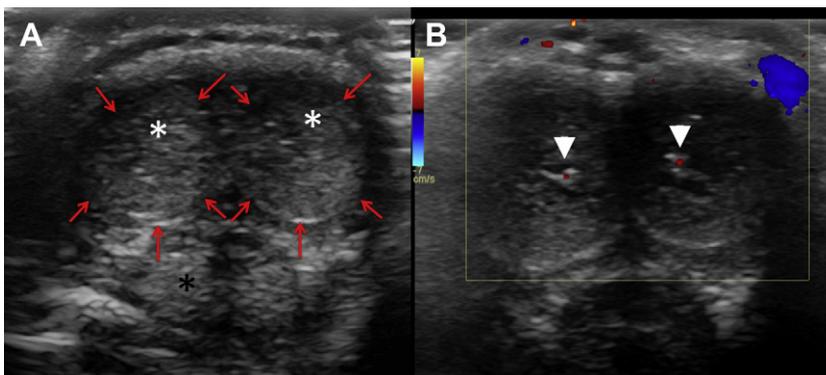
Normal penile anatomy on ultrasound. (A) Gray-scale image demonstrates the corpora cavernosa (white asterisks) and corpus spongiosum (black asterisk). The tunica albuginea, best seen ventrally, is indicated with red arrows. (B) Color-scale image demonstrates small areas of color flow in the central arteries of each corpus cavernosum (arrowheads).
